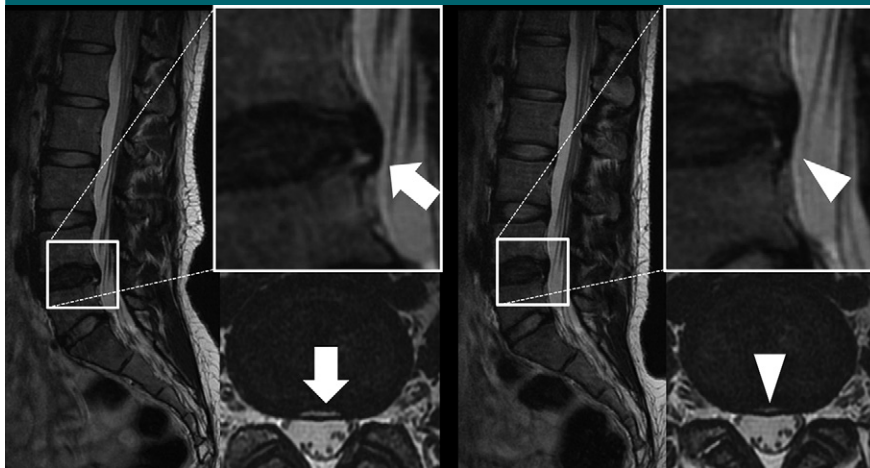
MR images show definite changes in disk shape before traction (left) and 30 minutes after traction (right). The HIZ at the posterior annulus is observed, and the shape of the disk is convex (arrows). The volume of herniated disk material is reduced 30 minutes after traction (arrowheads). Reduction of herniated disk volume is also seen in axial views (lower right images).
